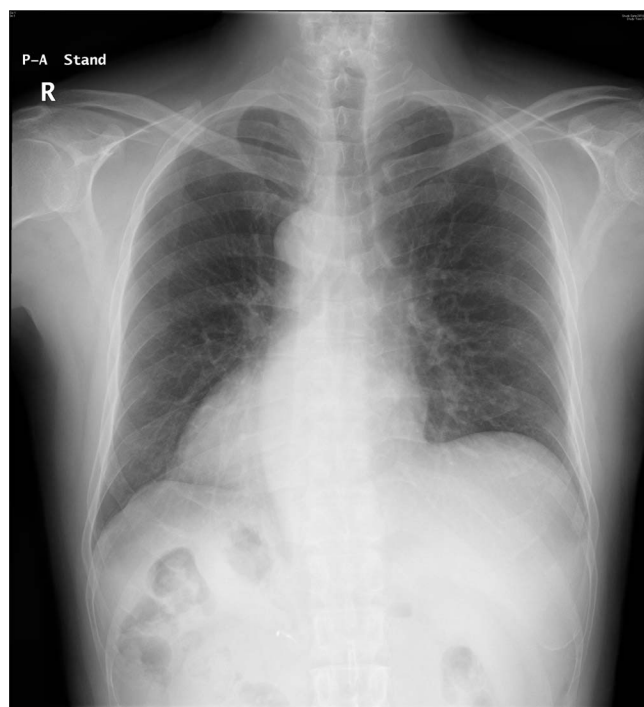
Dextrocardia is evident on chest radiography from the frontal view.
